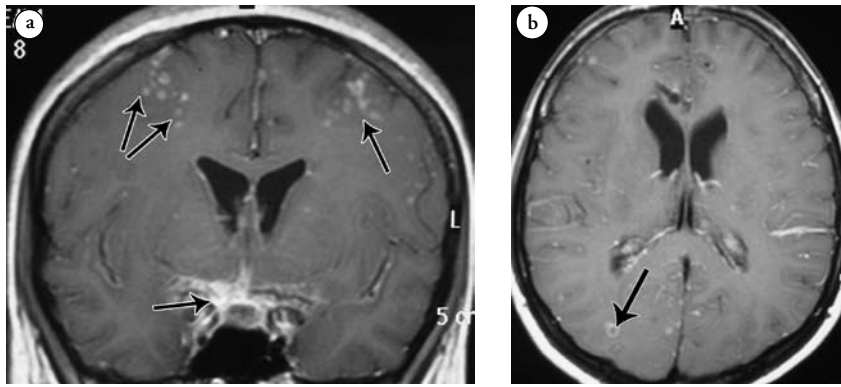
Tuberculoma in the cranial MRI of a patient with tuberculous meningitis. a) Coronal T1-weighted with contrast enhancement MR scan shows bilateral multiple millimetric nodular parenchymal lesions (arrows) (tuberculoma). There is a dense contrast enhancement, which shows basal involvement. b) Axial T1-weighted with contrast enhancement MR scan shows multiple parenchymal nodular lesions (arrows).
